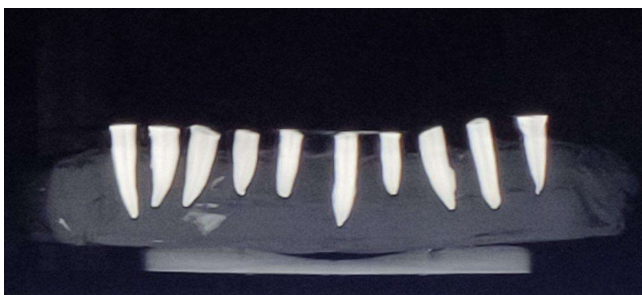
CBCT scan of decoronated view represented from the frontal aspect
